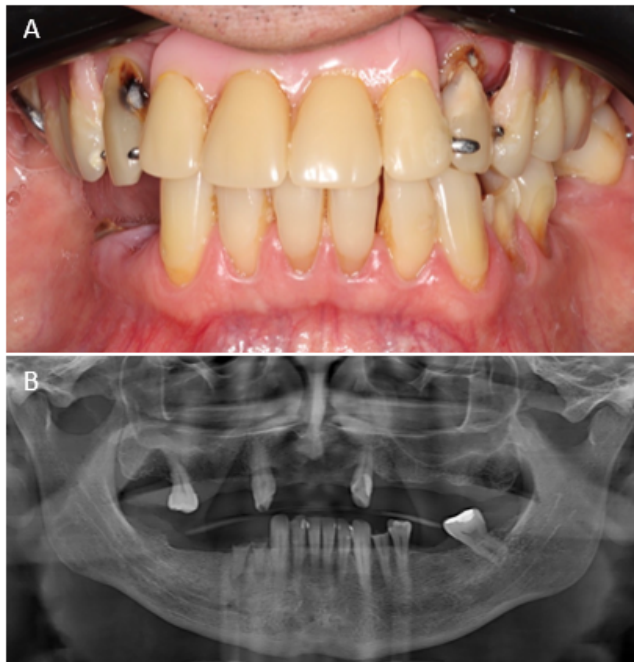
Intraoral frontal view with patient's upper partial dentures (A). Initial panoramic radiography showing the absence of several teeth in both arches (B).
